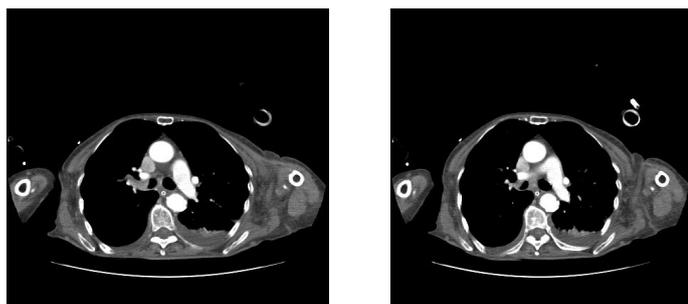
CT scan chest, fourth day in ITU after clot extraction showing intra-luminal space occupying lesion in the right main bronchus and was extending downward.
